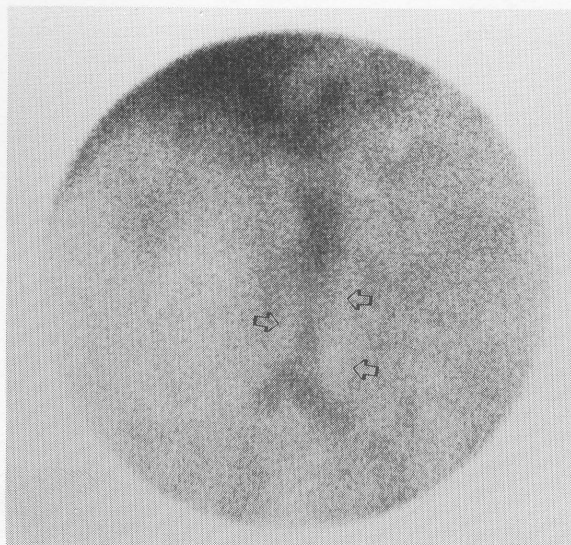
Eccentric thrombus manifested by photopenia along one side of the lumen: A 57-yr-old man (5071, DK) was found to have an abdominal aneurysm on a routine physical exam. First pass radionuclide study (A) shows angulation and photopenic area along the left aneurysmal wall (arrow). The findings persist on blood pool images (B). CT of the abdomen (C) shows thrombus mainly on the left side of the aneurysmal lumen.
